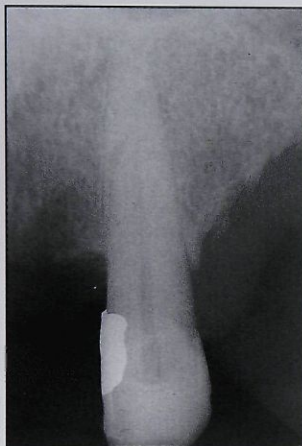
(left) Nine-month postoperative radiograph showing fill of the bony defect.
